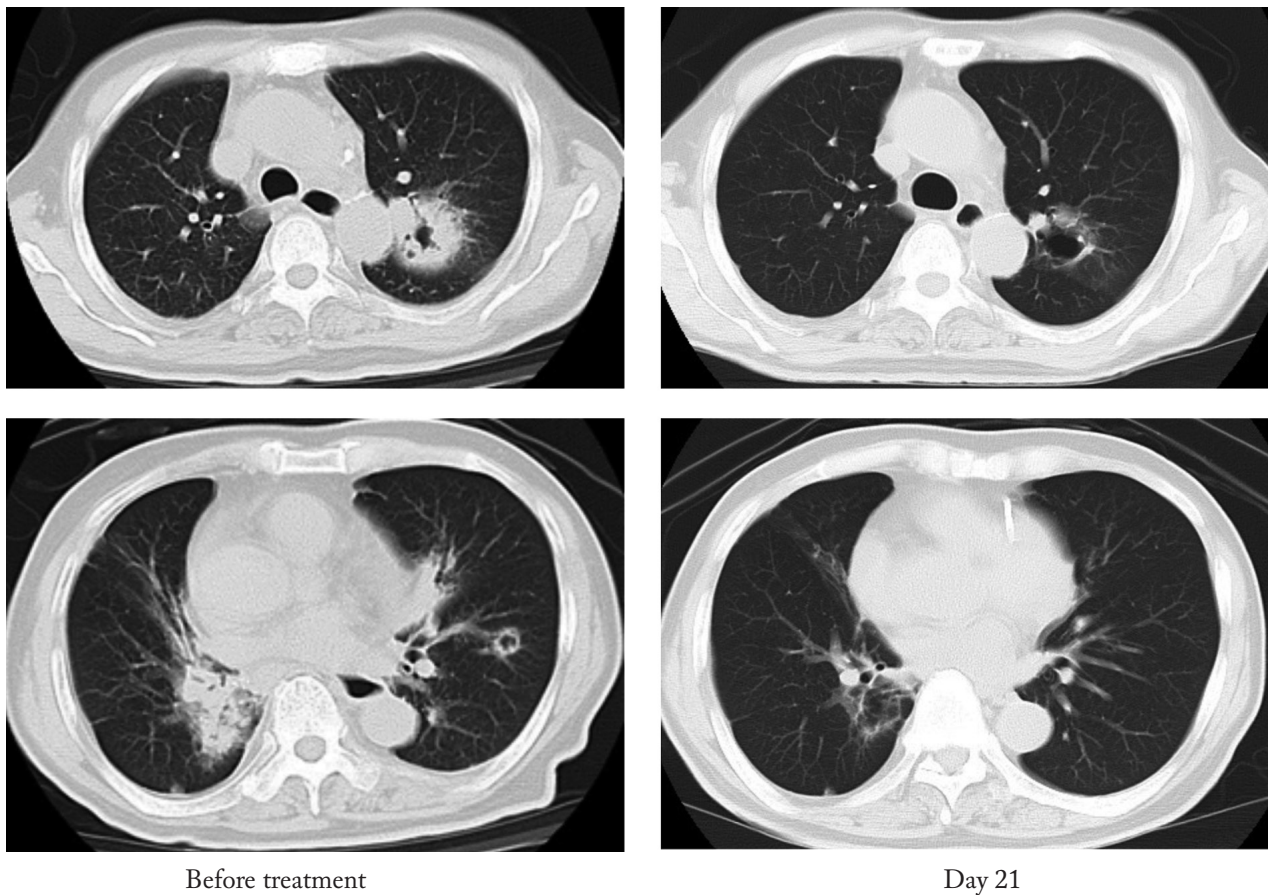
Clinical course of chest computed tomography (CT) images before and after the treatment to granulomatosis with polyangiitis. Chest CT before the treatment (left upper and left bottom) and at day 21 after the treatment (right upper and right bottom)
